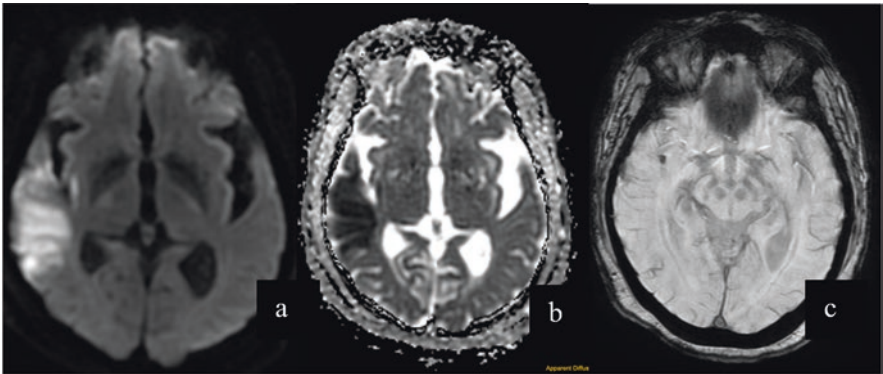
Axial MRI images of the brain showing an acute infarct in the right middle cerebral artery (MCA) territory secondary to a thrombus in the inferior division of the right middle cerebral artery. Diffusion weighted image (a) showing restricted diffusion in the right temporal region with loss of ADC values. (b) An area of blooming seen on SWAN images in the inferior division of right MCA (c)
